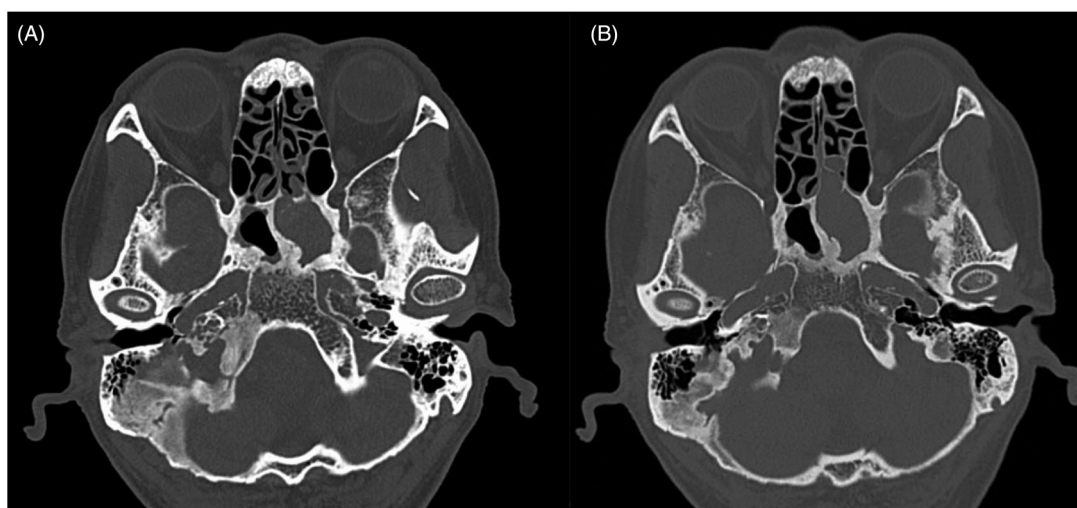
CT imaging during hormonal therapy. The bone sclerosis lesion has been shrinking by the hormonal therapy. (A) 3 months after the start of hormonal therapy. (B) 18 months after the start of hormonal therapy.
